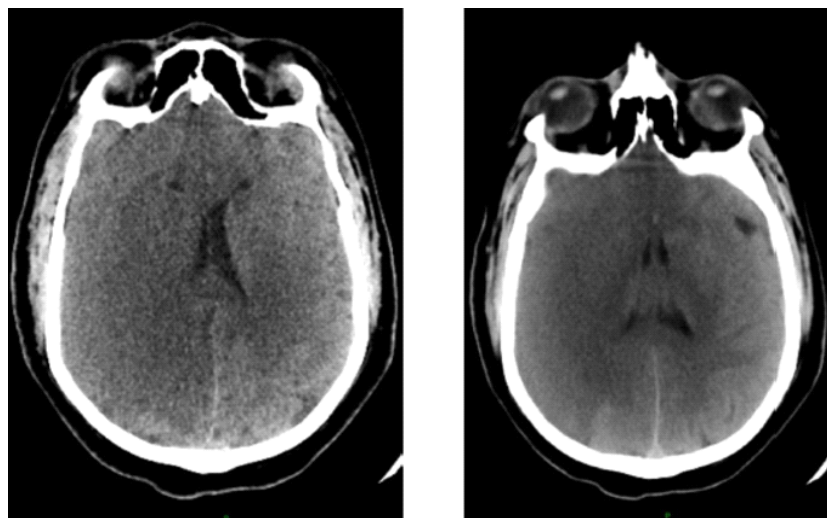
Non-contrast computed tomography brain suggestive of a large acute infarction involving the right cerebral hemisphere and left frontal region.
